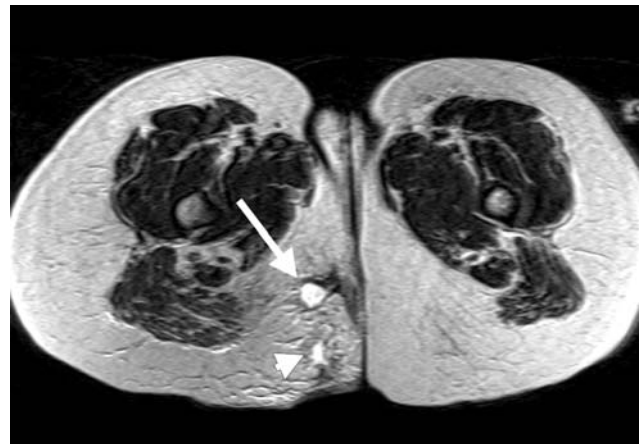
Axial T2-weighted MR image shows an abscess (arrow) in the right ischioanal space. A secondary track is also visible within this fossa (arrowhead).
